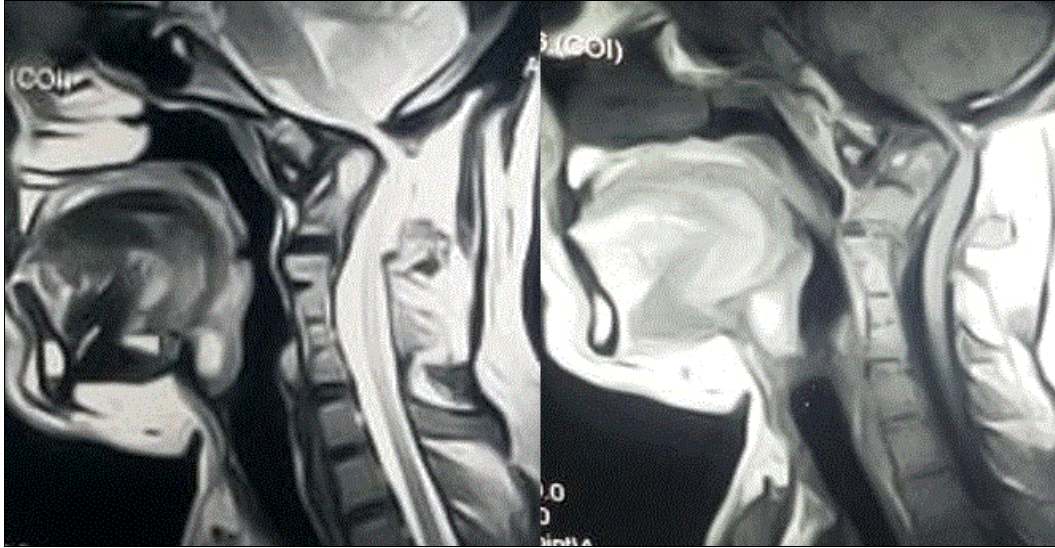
T2 and T1 weighted MRI shows significant compression of the spinal cord.
